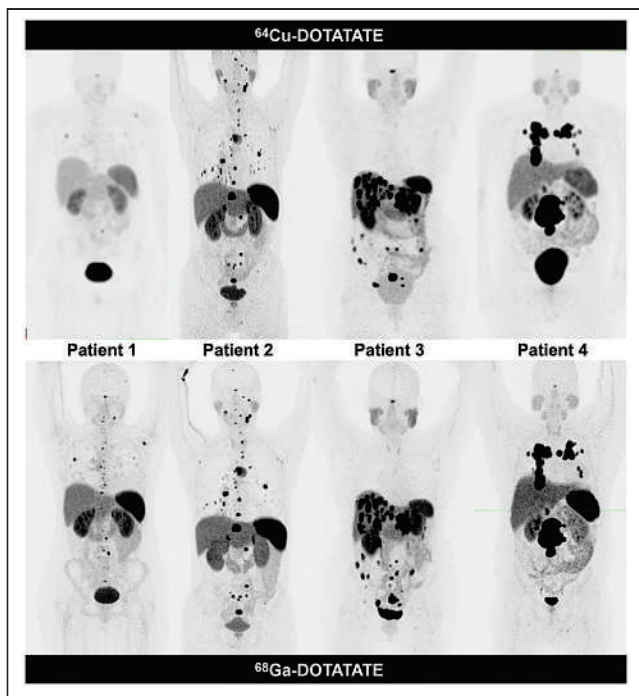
SSTR imaging with ^{64}Cu Cu-DOTATATE and ^{68}Ga Ga-DOTATATE in PPGL. Figure shows maximum-intensity projection images in 4 patients who underwent imaging with both ^{64}Cu Cu-DOTATATE (top panel) and ^{68}Ga Ga-DOTATATE (bottom panel). Leveling of all maximum-intensity projection images is at same SUV_{max} , ranging from 0 to 14.
